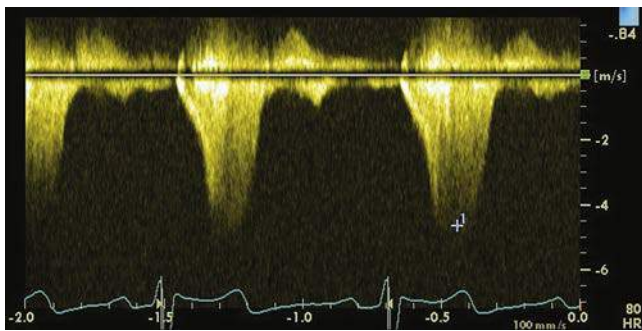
Continuous wave Doppler image of the left ventricular outflow tract in a patient with obstructive hypertrophic cardiomyopathy. Note the characteristic dagger shape with a late systolic peak.
